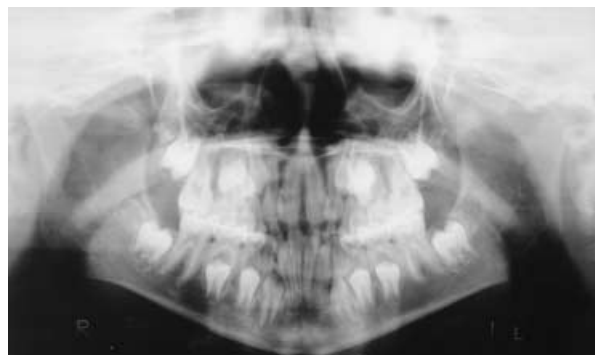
Panoramic radiograph taken when the subject was 9 years and 7 months old.
